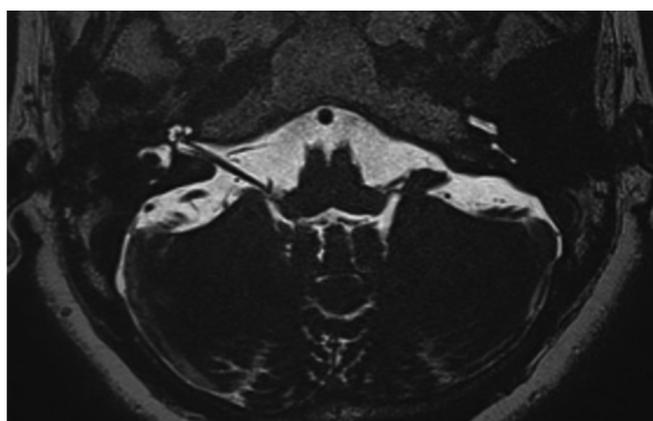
Magnetic resonance image of a right-sided Type 1A vascular loop in a 58-year-old female patient with right-sided tinnitus.
